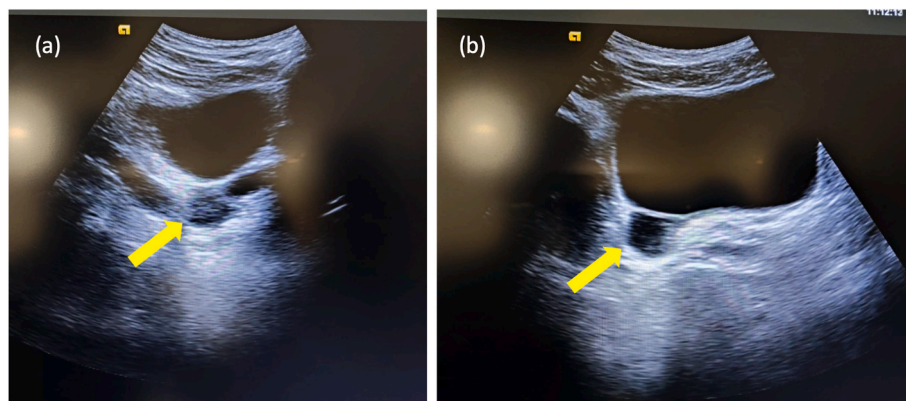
(a) Axial section; (b) sagittal section. Bladder ultrasonography revealed a hypoechoic lesion located on the right dorsal aspect of the bladder (yellow arrow).
